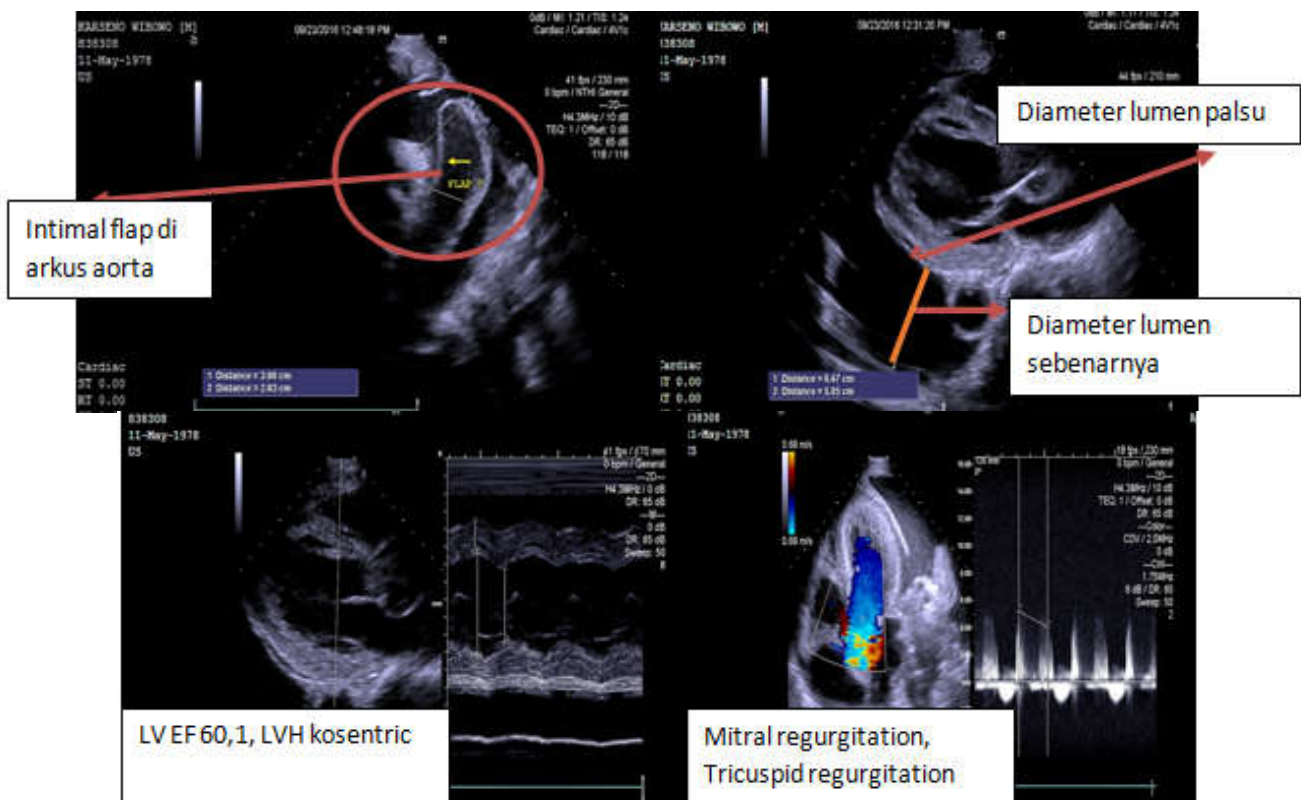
Echocardiography showed intimal flap, true lumen, and false lumen (red circle and arrow)
